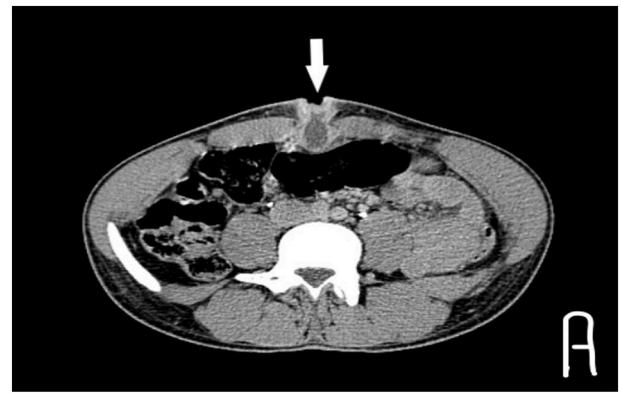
Computed tomographic scan of the abdomen showing: A. Urachal sinus (coronal section). B. Obliterated median umbilical ligament & urinary bladder (sagittal section).
